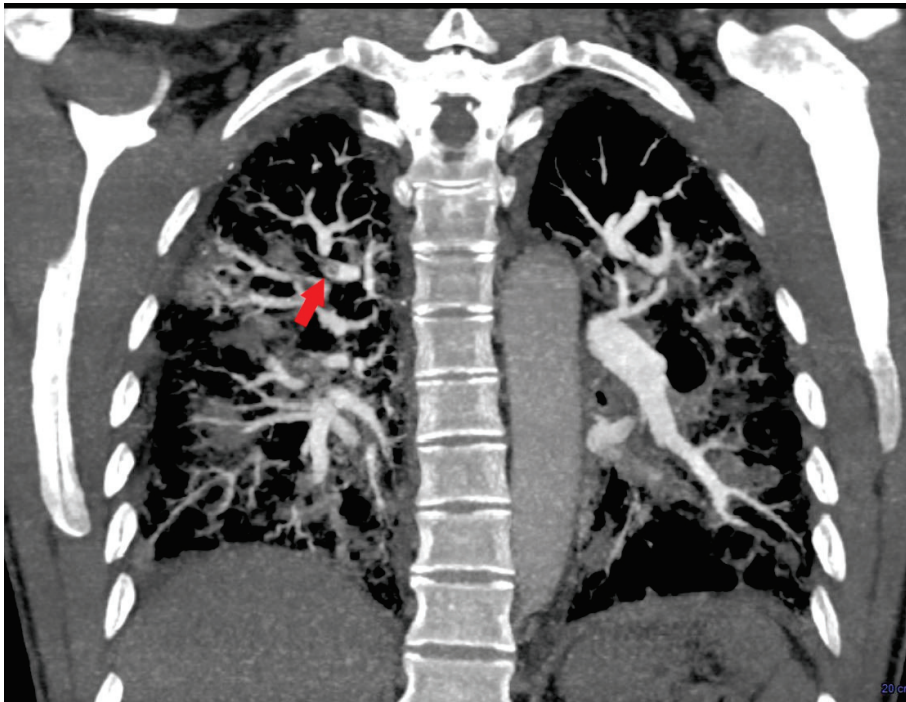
Coronal contrast-enhanced chest computed tomography revealing segmental and subsegmental filling defects (red arrow) in the right upper lobe.
